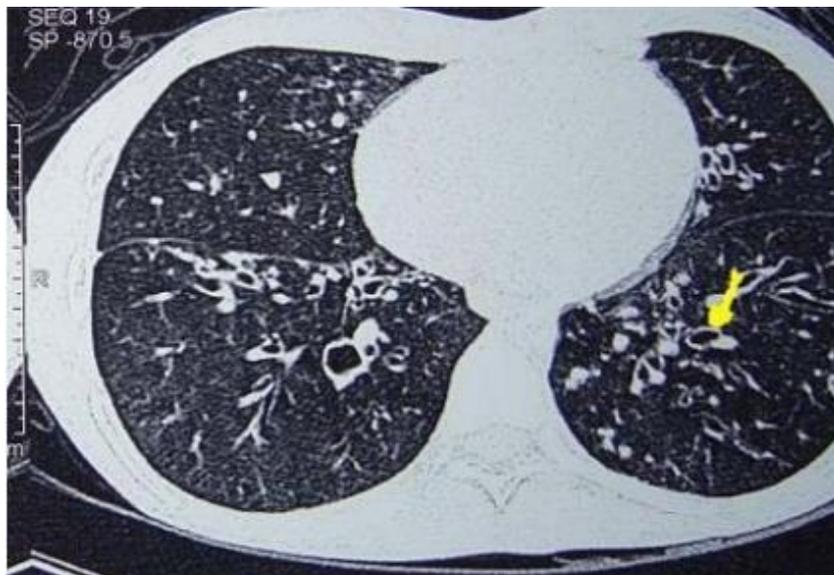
HRCT in a patient with cystic bronchiectasis showing dilatation of the bronchioles with thickening of their walls. Signet ring appearance depicted by yellow arrow, image by Ibraham *et al* [51]
